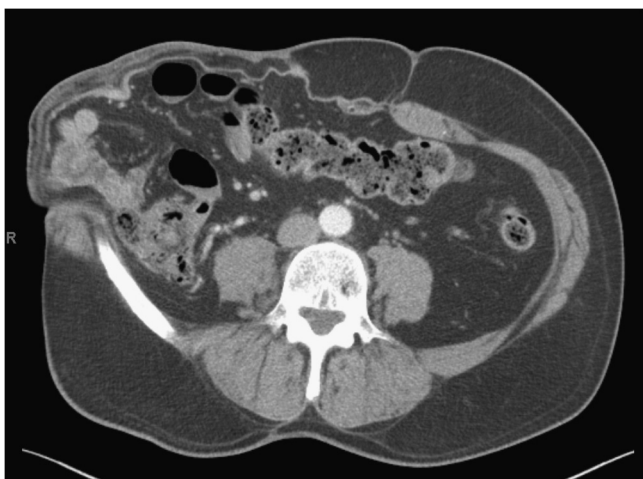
CT-scan of bulging mesh four years after reconstruction (2012).
